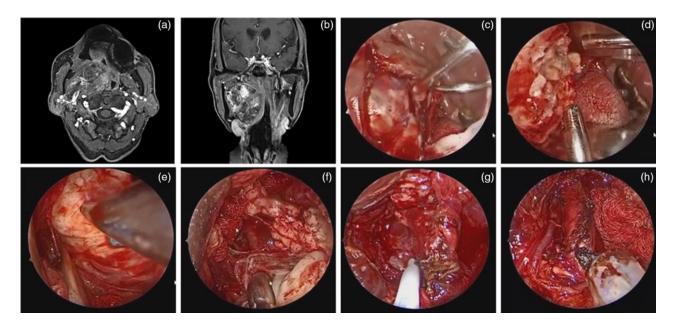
Pre-operative enhanced magnetic resonance imaging scans in (a) axial and (b) coronal planes showing a huge pleomorphic adenoma (case 5). (c-f) Endoscopic images showing an internal debulking that was performed to avoid injury to surrounding vital structures and to avoid the risk of an unrecognised spillage, with (c) showing exposure of the tumour, (d) showing internal debulking after excision of the tumour capsule, (e) showing complete removal of the tumour and (f) showing haemostasis after tumour removal. (g) Endoscopic image showing the internal carotid artery, which was recognised by the ultrasonic Doppler system after tumour removal. (h) Endoscopic image showing the styloid process that was recognised in the operative cavity.
